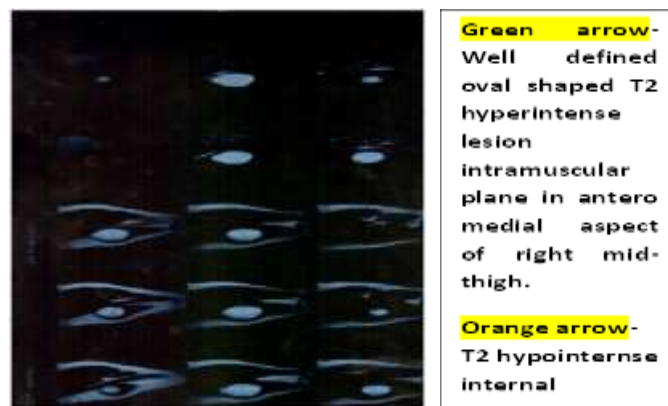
MRI shows well defined, T2/STIR hyperintense lesion with internal septation
